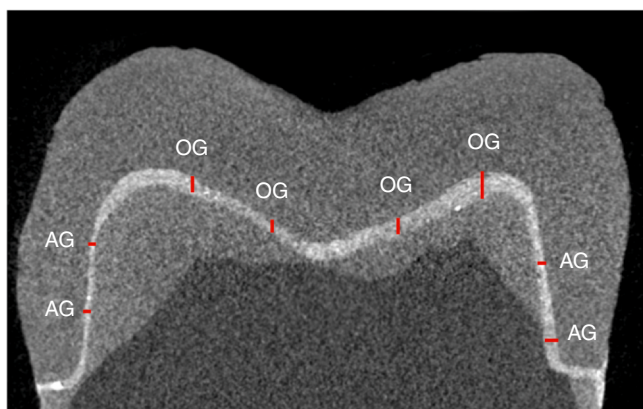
Microcomputed tomography scan image (vertical cut): measurement of axial gap (AG) and occlusal gap (OG) (measured distances perpendicular to ceramic restoration and tooth internal surfaces at selected points).
